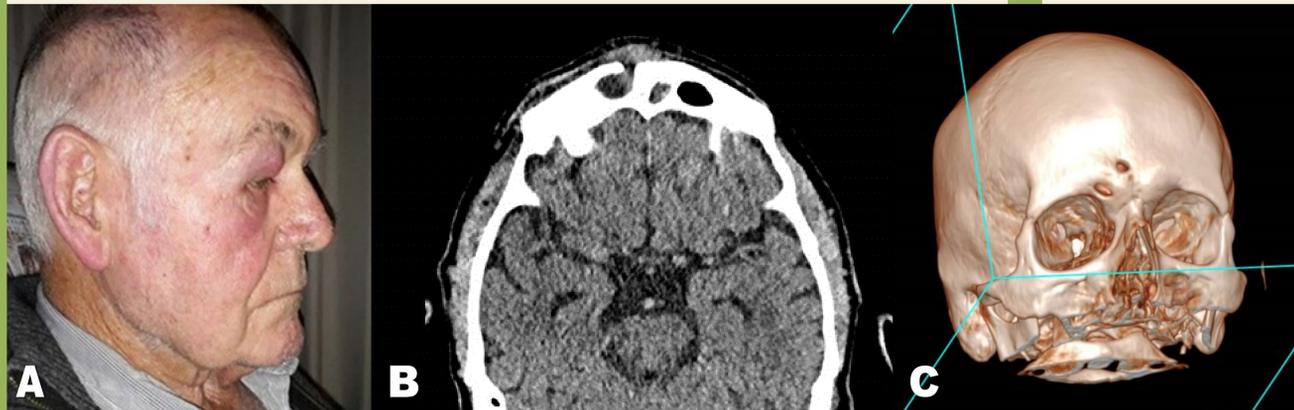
Photo (A) shows patient with palpebral abscess. CT (B) demonstrates right frontal sinus opacification with associated subperiosteal abscess as well as new bone formation in the frontal sinus. Picture (C) is a 3D reconstruction of the CT showing the dehiscences of the frontal sinus
